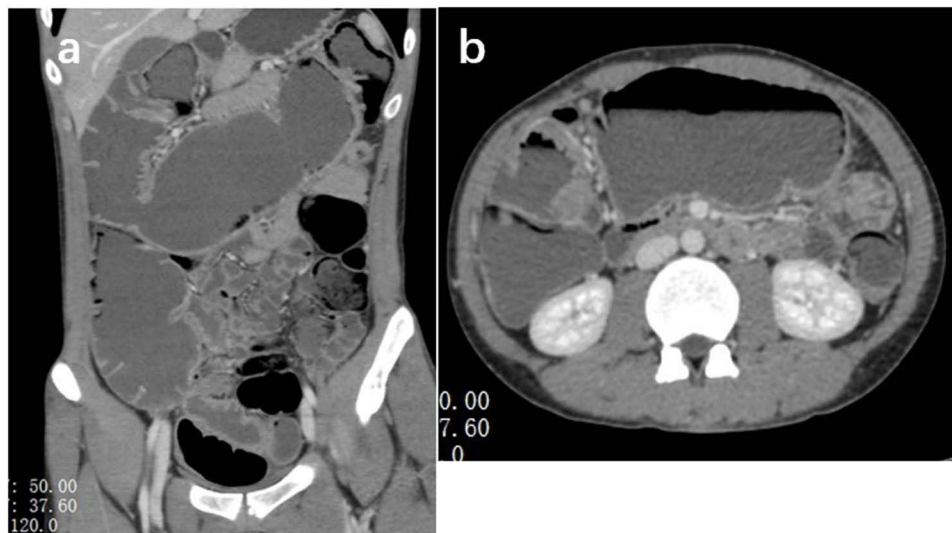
(a and b) Abdominal CT scan indicates gas and fluid accumulation inside the colon and small intestine.
